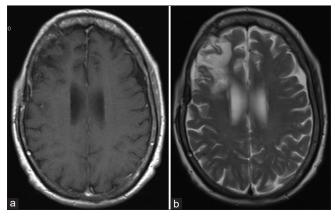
Postoperative magnetic resonance imaging. (a and b) Axial T1-weighted with gadolinium and axial T2-weighted images showing postsurgical changes and gross total resection.
